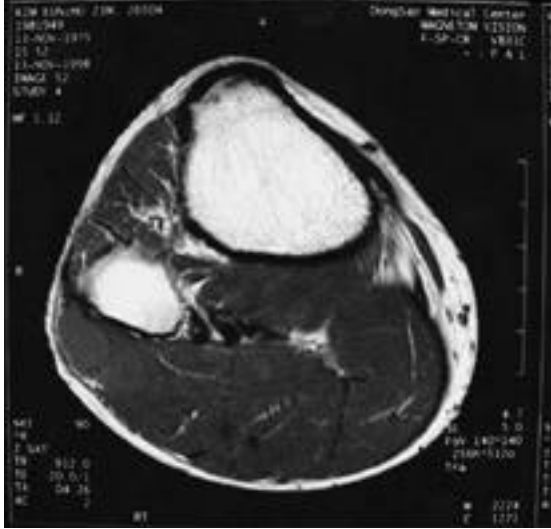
T1-weighted images (TR/TE: 912/20) transverse images show a mass at just below the knee level. The ganglion cyst is seen as round mass of intermediate signal intensity near the fibular neck.
